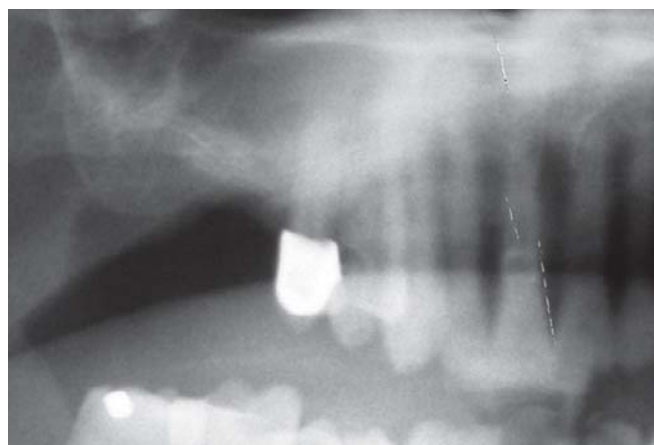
Postoperative radiograph for the 1st stage of lateral window SFE
